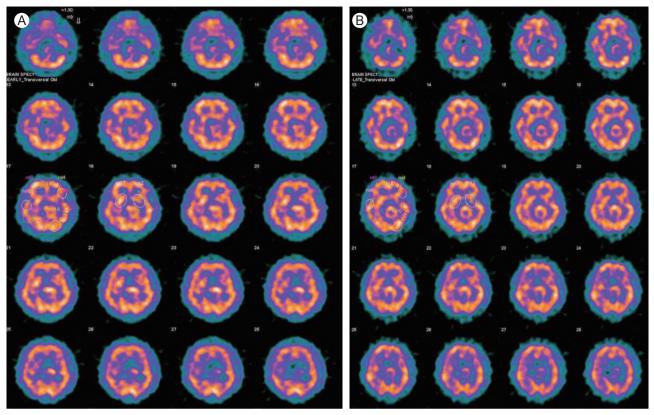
Radionuclide resting cerebral blood flow (rCBF) study with 600 MBq ^{99m}Tc-ECD baseline (A), and 800 MBq ^{99m}Tc-ECD after injection of 1,000 mg acetazolamide (B) by single-photon emission computed tomography (SPECT) showed no definite blood flow abnormality in the cerebral hemispheres.
